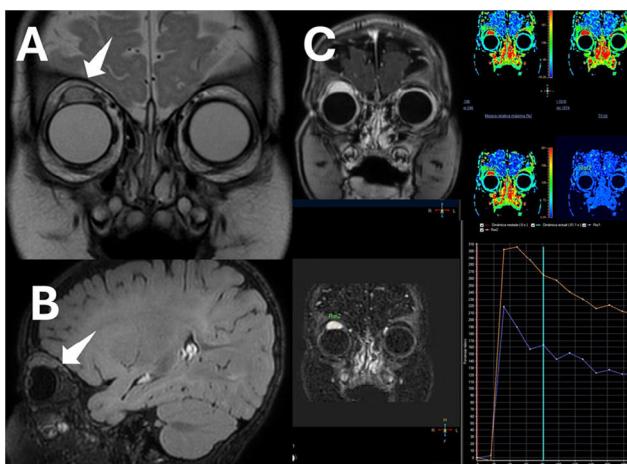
Magnetic resonance imaging. (A) Coronal view and (B) sagittal view showing a homogeneous lesion, hyperintense on T2-weighted imaging, in the distal portion of the superior rectus muscle of the right eye, near the insertion on the globe, measuring $16 \times 14 \times 16$ mm (anteroposterior \times transverse \times craniocaudal diameters), with a hypointense border corresponding to a pseudocapsule, showing facilitated diffusion, without calcification or bleeding within the lesion. (C) Dynamic contrast-enhanced MRI, fat-suppressed T1-weighted images showing a type 3 kinetic curve with a rapid uptake followed by a progressive reduction on the late phase (washout). Post-contrast imaging of the right superior rectus muscle showing homogeneous enhancement.
